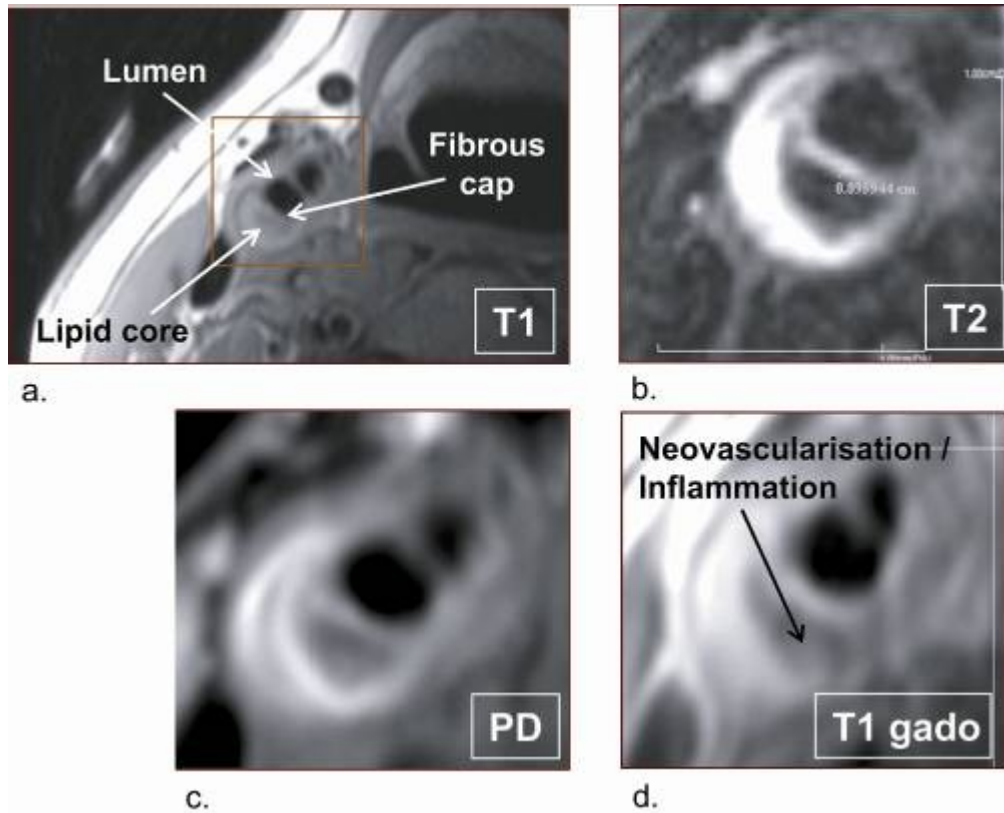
Cross-sectional high-resolution MRI of an asymptomatic patient's right internal carotid artery plaque. This patient has a 50% stenosis. (a) T1-weighted image showing a thick fibrous cap and large lipid core, easier to depict on the corresponding post-gadolinium injection T1-weighted image in (d). (b) A drop in relative signal intensity on this T2-weighted image (compared to other sequences) characterizes the presence of a lipid-rich necrotic core. (c) Proton density image shows an isointense core. (d) After gadolinium injection, plaque enhancement is observed in the postero-medial aspect of the plaque, suggesting neovascularisation or inflammation.
